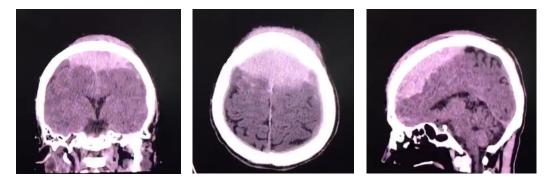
Case 2. Computed tomography of the skull showed an epidural hematoma in coronal, axial and sagittal sections, demonstrating its clear surgical indication and the presence of subgaleal hematoma in relation to the fracture site.
